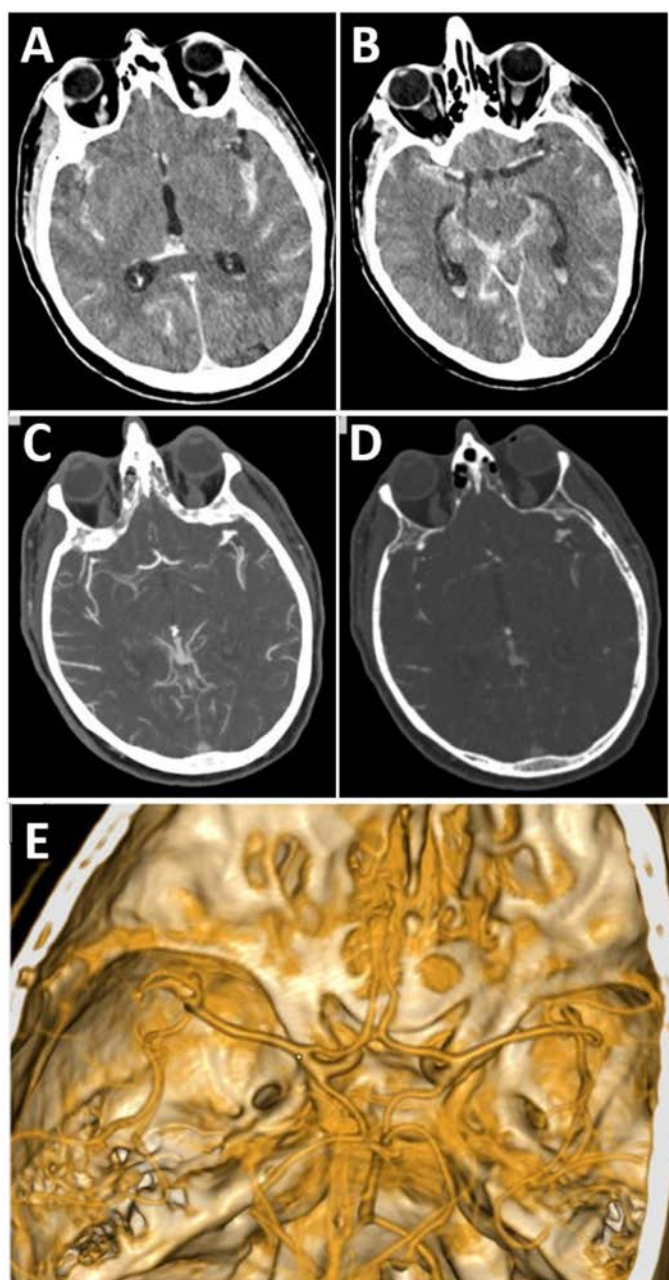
A, B. Preoperative imaging demonstrating aneurysmal subarachnoid hemorrhage and a ruptured left middle cerebral artery bifurcation aneurysm. Non-contrast head computed tomography shows diffuse subarachnoid hemorrhage involving the basal cisterns and bilateral sylvian fissures, with associated intraventricular hemorrhage and acute hydrocephalus, corresponding to modified Fisher grade IV hemorrhage. C, D, E. Axial computed tomography angiography images and three-dimensional vascular reconstruction demonstrate a multilobulated aneurysm arising from the left middle cerebral artery bifurcation with incorporation of an M2 branch. No pseudoaneurysmal component was identified on preoperative vascular imaging.
